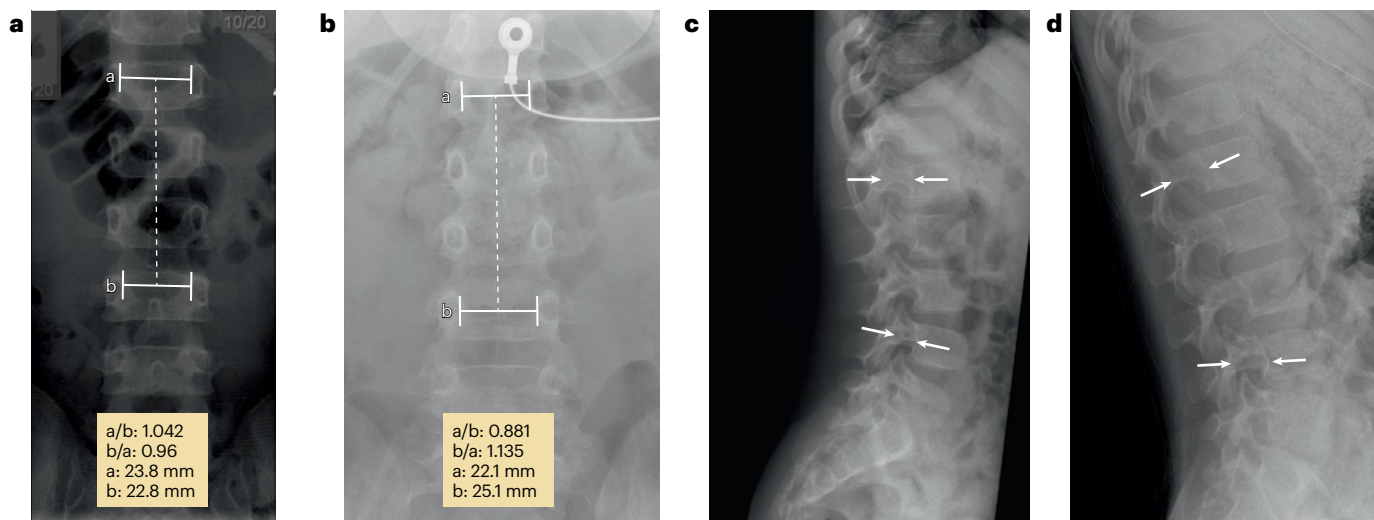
Radiographs showing key features of hypochondroplasia.
